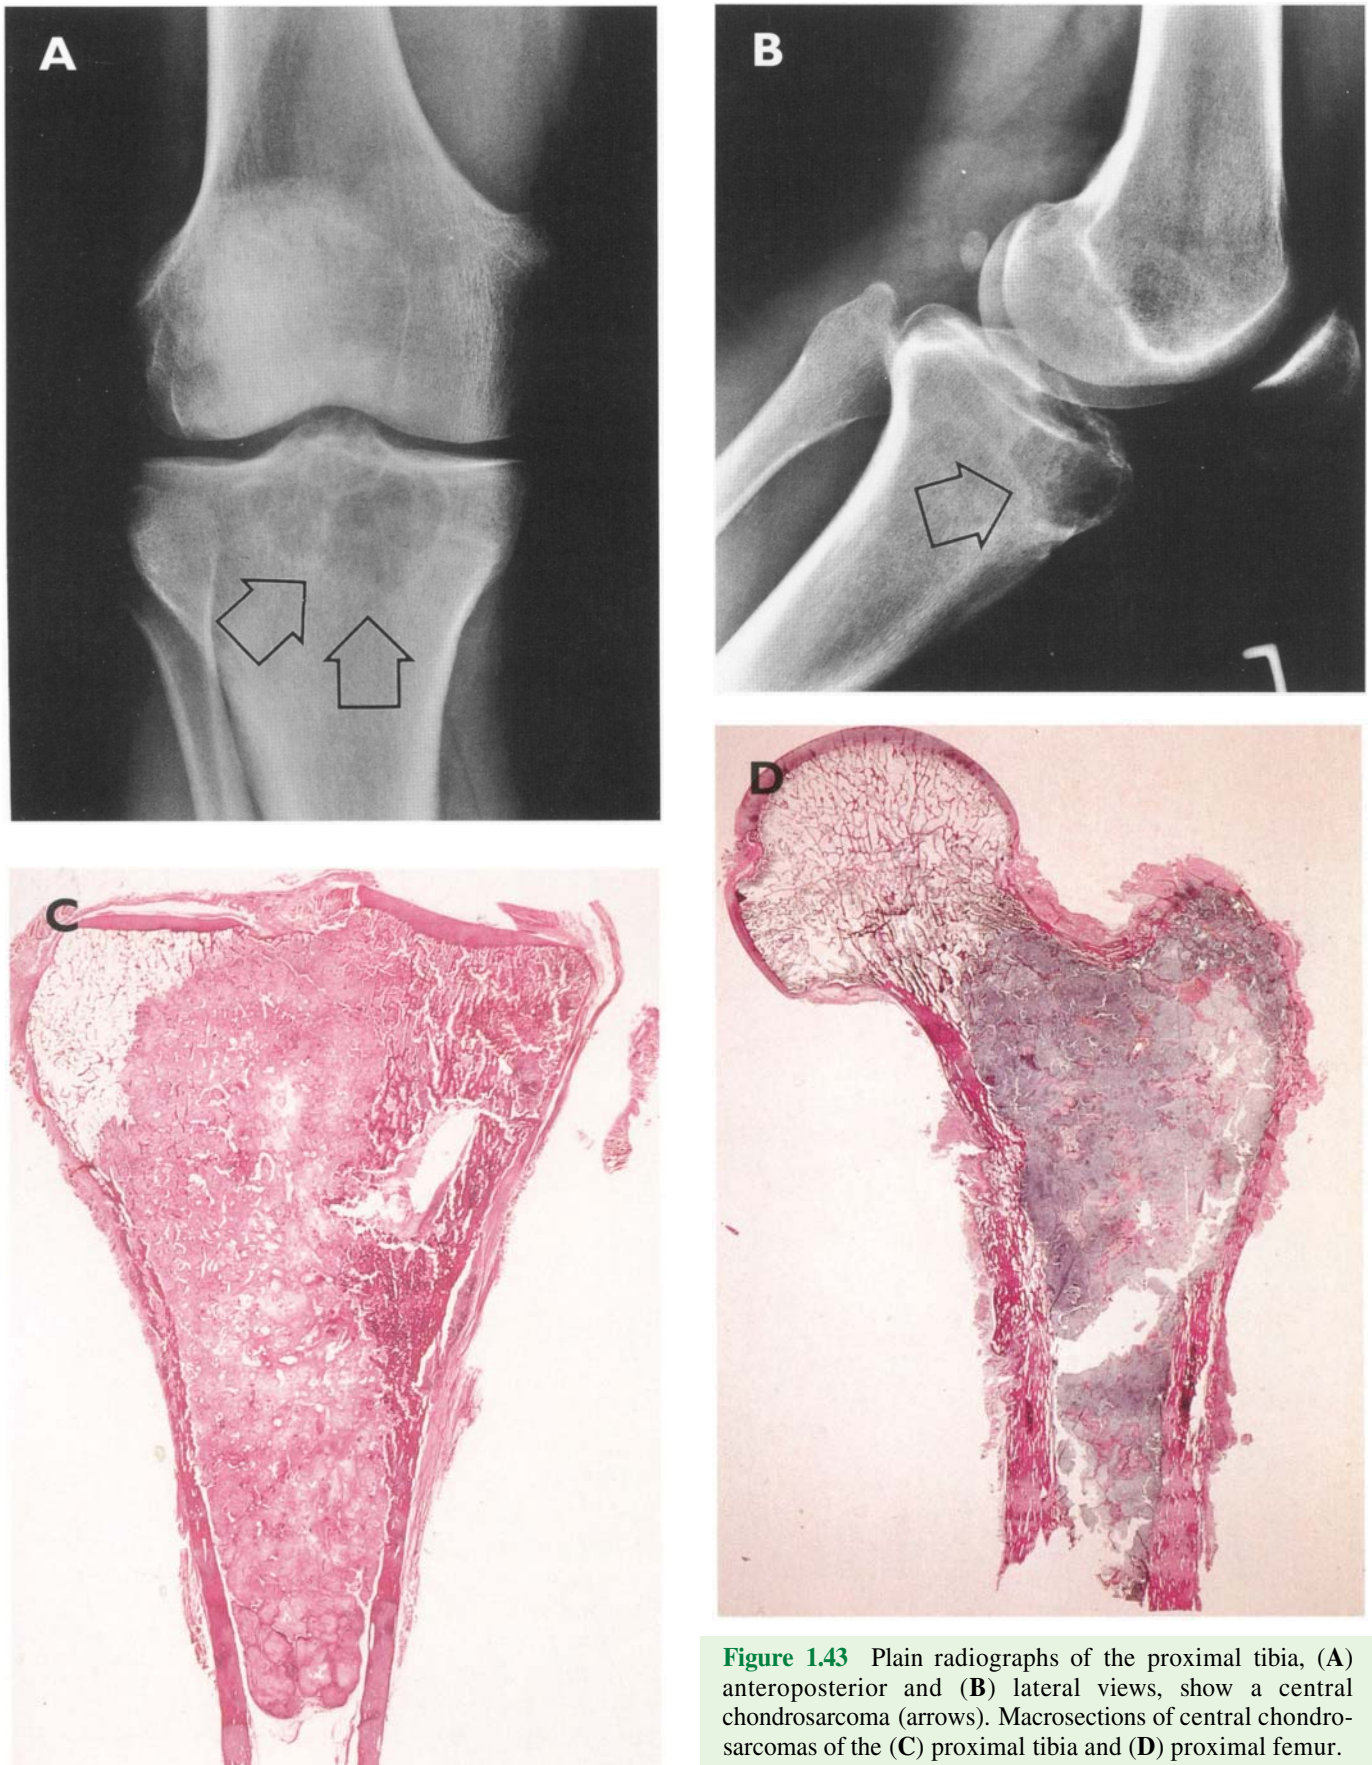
Plain radiographs of the proximal tibia, (A) anteroposterior and (B) lateral views, show a central chondrosarcoma (arrows). Macrosections of central chondrosarcomas of the (C) proximal tibia and (D) proximal femur.
